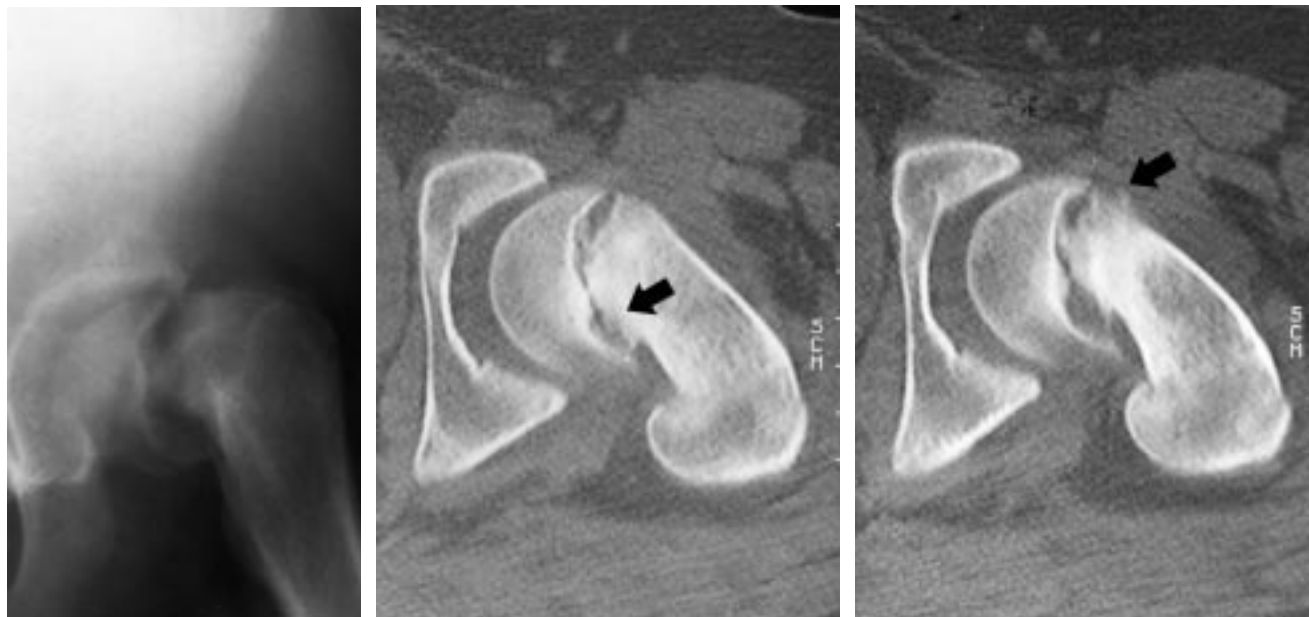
Plain radiographic and CT images of the hip of a 90-kg 11-year-old girl with an acute-on-chronic SCFE. Note remodeling changes (arrows) in the femoral neck.
